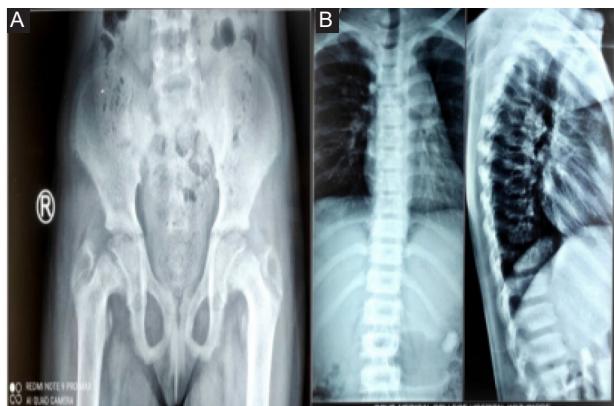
(A) X-Ray of hip showing bilateral slipped capital femoral epiphysis. (B) X-ray of the spine showing Rugger jersey appearance.
